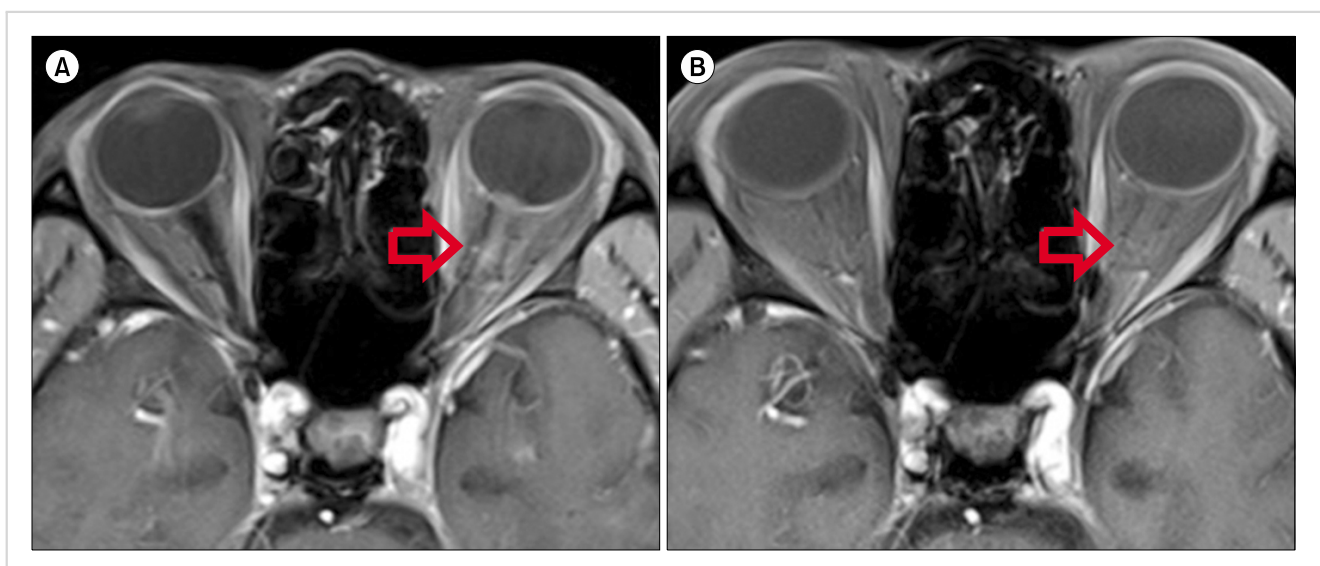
(A) Gadolinium-enhanced, T1-weighted magnetic resonance imaging shows mild thickening and enhancement of the left optic nerve. (B) The optic nerve thickening was resolved after three cycles of R-BAD (rituximab, bendamustine, cytarabine, and dexamethasone) chemotherapy.
